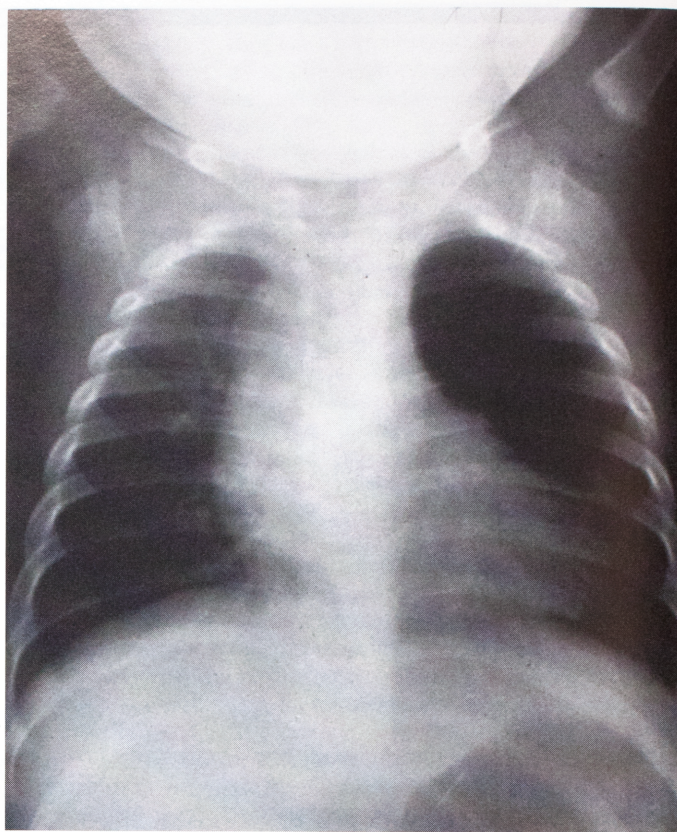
In the chest x-ray film of a patient with congenital lobar emphysema, the mediastinum is displaced toward the right side by a hyperinflated left upper lobe (see Color Fig. 8-2). (Courtesy of Daphne deMello, M.D., St. Louis, MO.)
